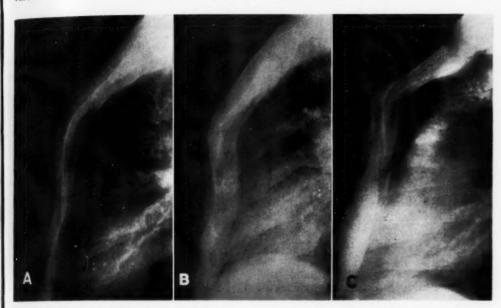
Three sterna showing a pronounced kyphosis and complete obliteration of all the sutures except for an extremely narrow radiolucent line at the manubriosternal junction, visible only in special oblique roentgen views of the chest.
